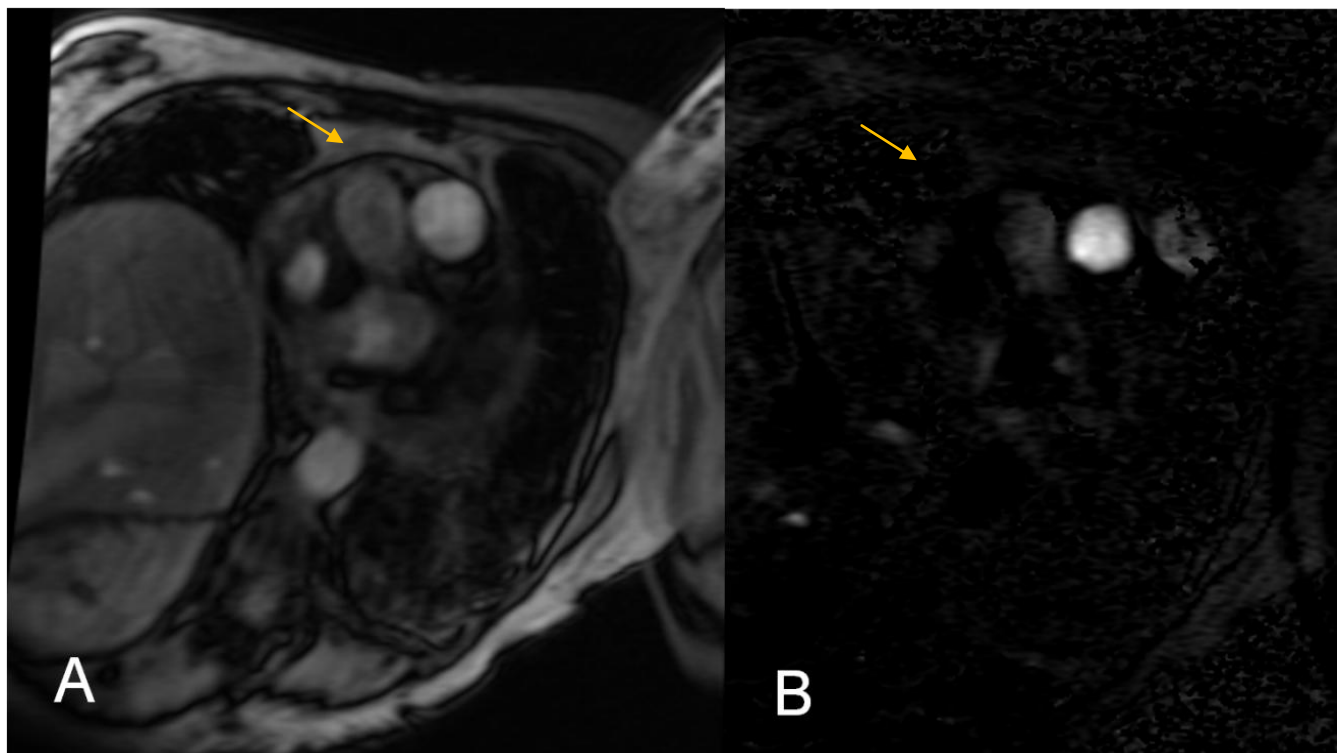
Magnitude (A) and velocity (B) encoded images from phase contrast MRI of the pulmonary artery (yellow arrow).
